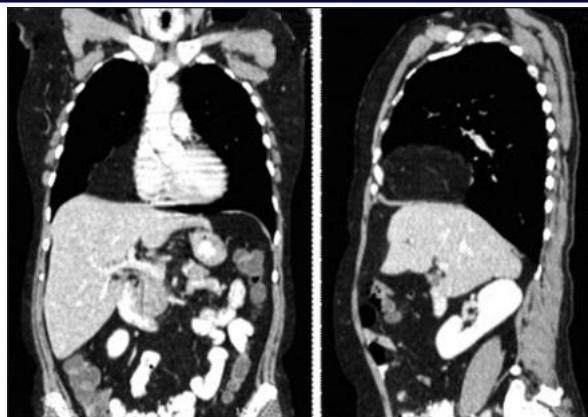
Morgagni hernia – CT: mass 110 x 80 mm, precisely defined, homogeneous, containing the falciform ligament and gastro-colonic epiploon, anterior located in the lower and middle mediastinum, compressing the adjacent pulmonary parenchyma
